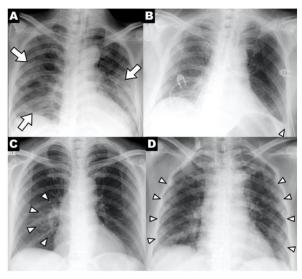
Chest x-ray findings in COVID-19: (A) patchy consolidations, (B) pleural effusion, (C) perihilar distribution, and (D) peripheral distribution.
